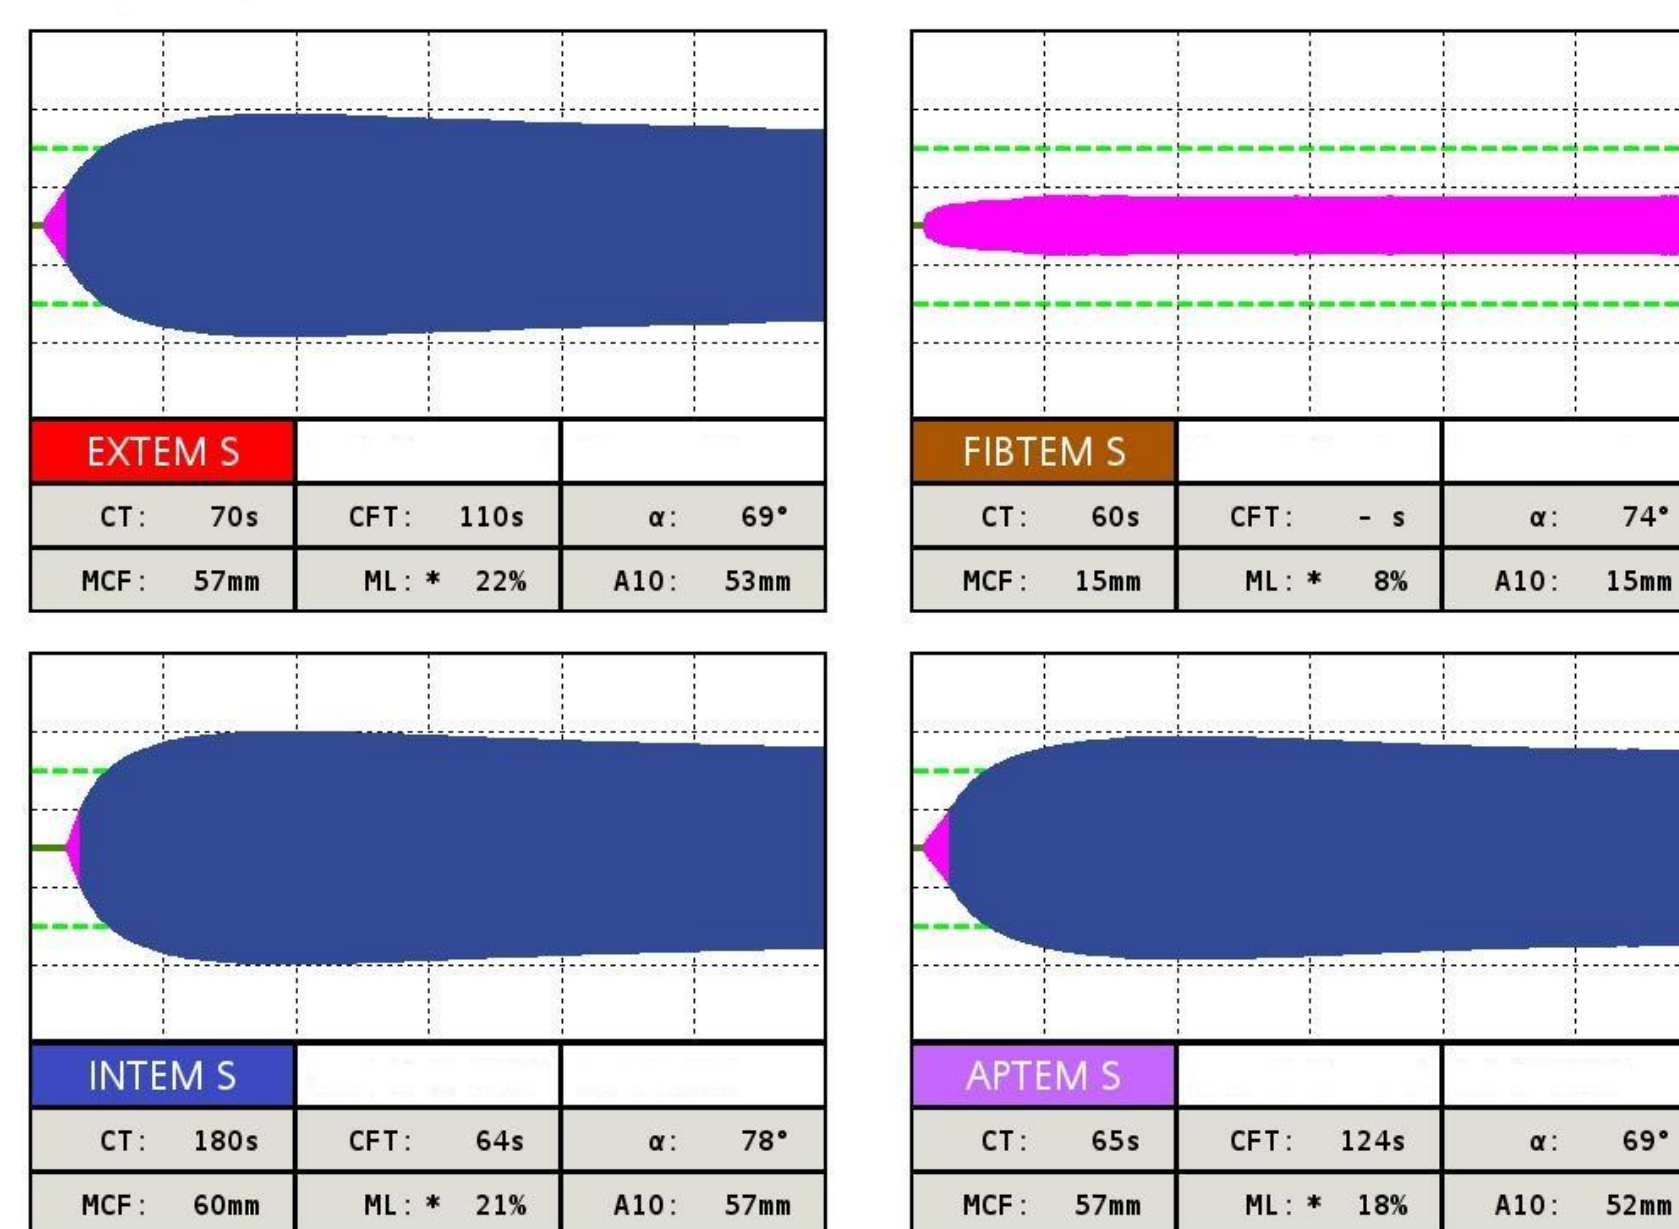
Normal clotting time (CT) in EXTEM, INTEM, FIBTEM and APTEM in APL-negative patient.
